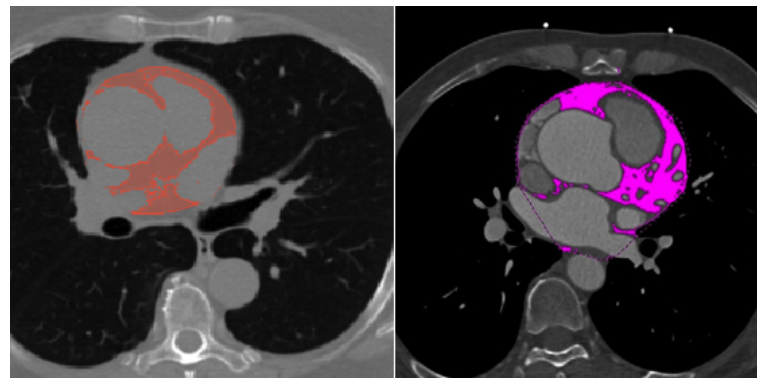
Segmented EAT in Non-Contrast (left) and Contrast-Enhanced (right) CT Images, from [18].
